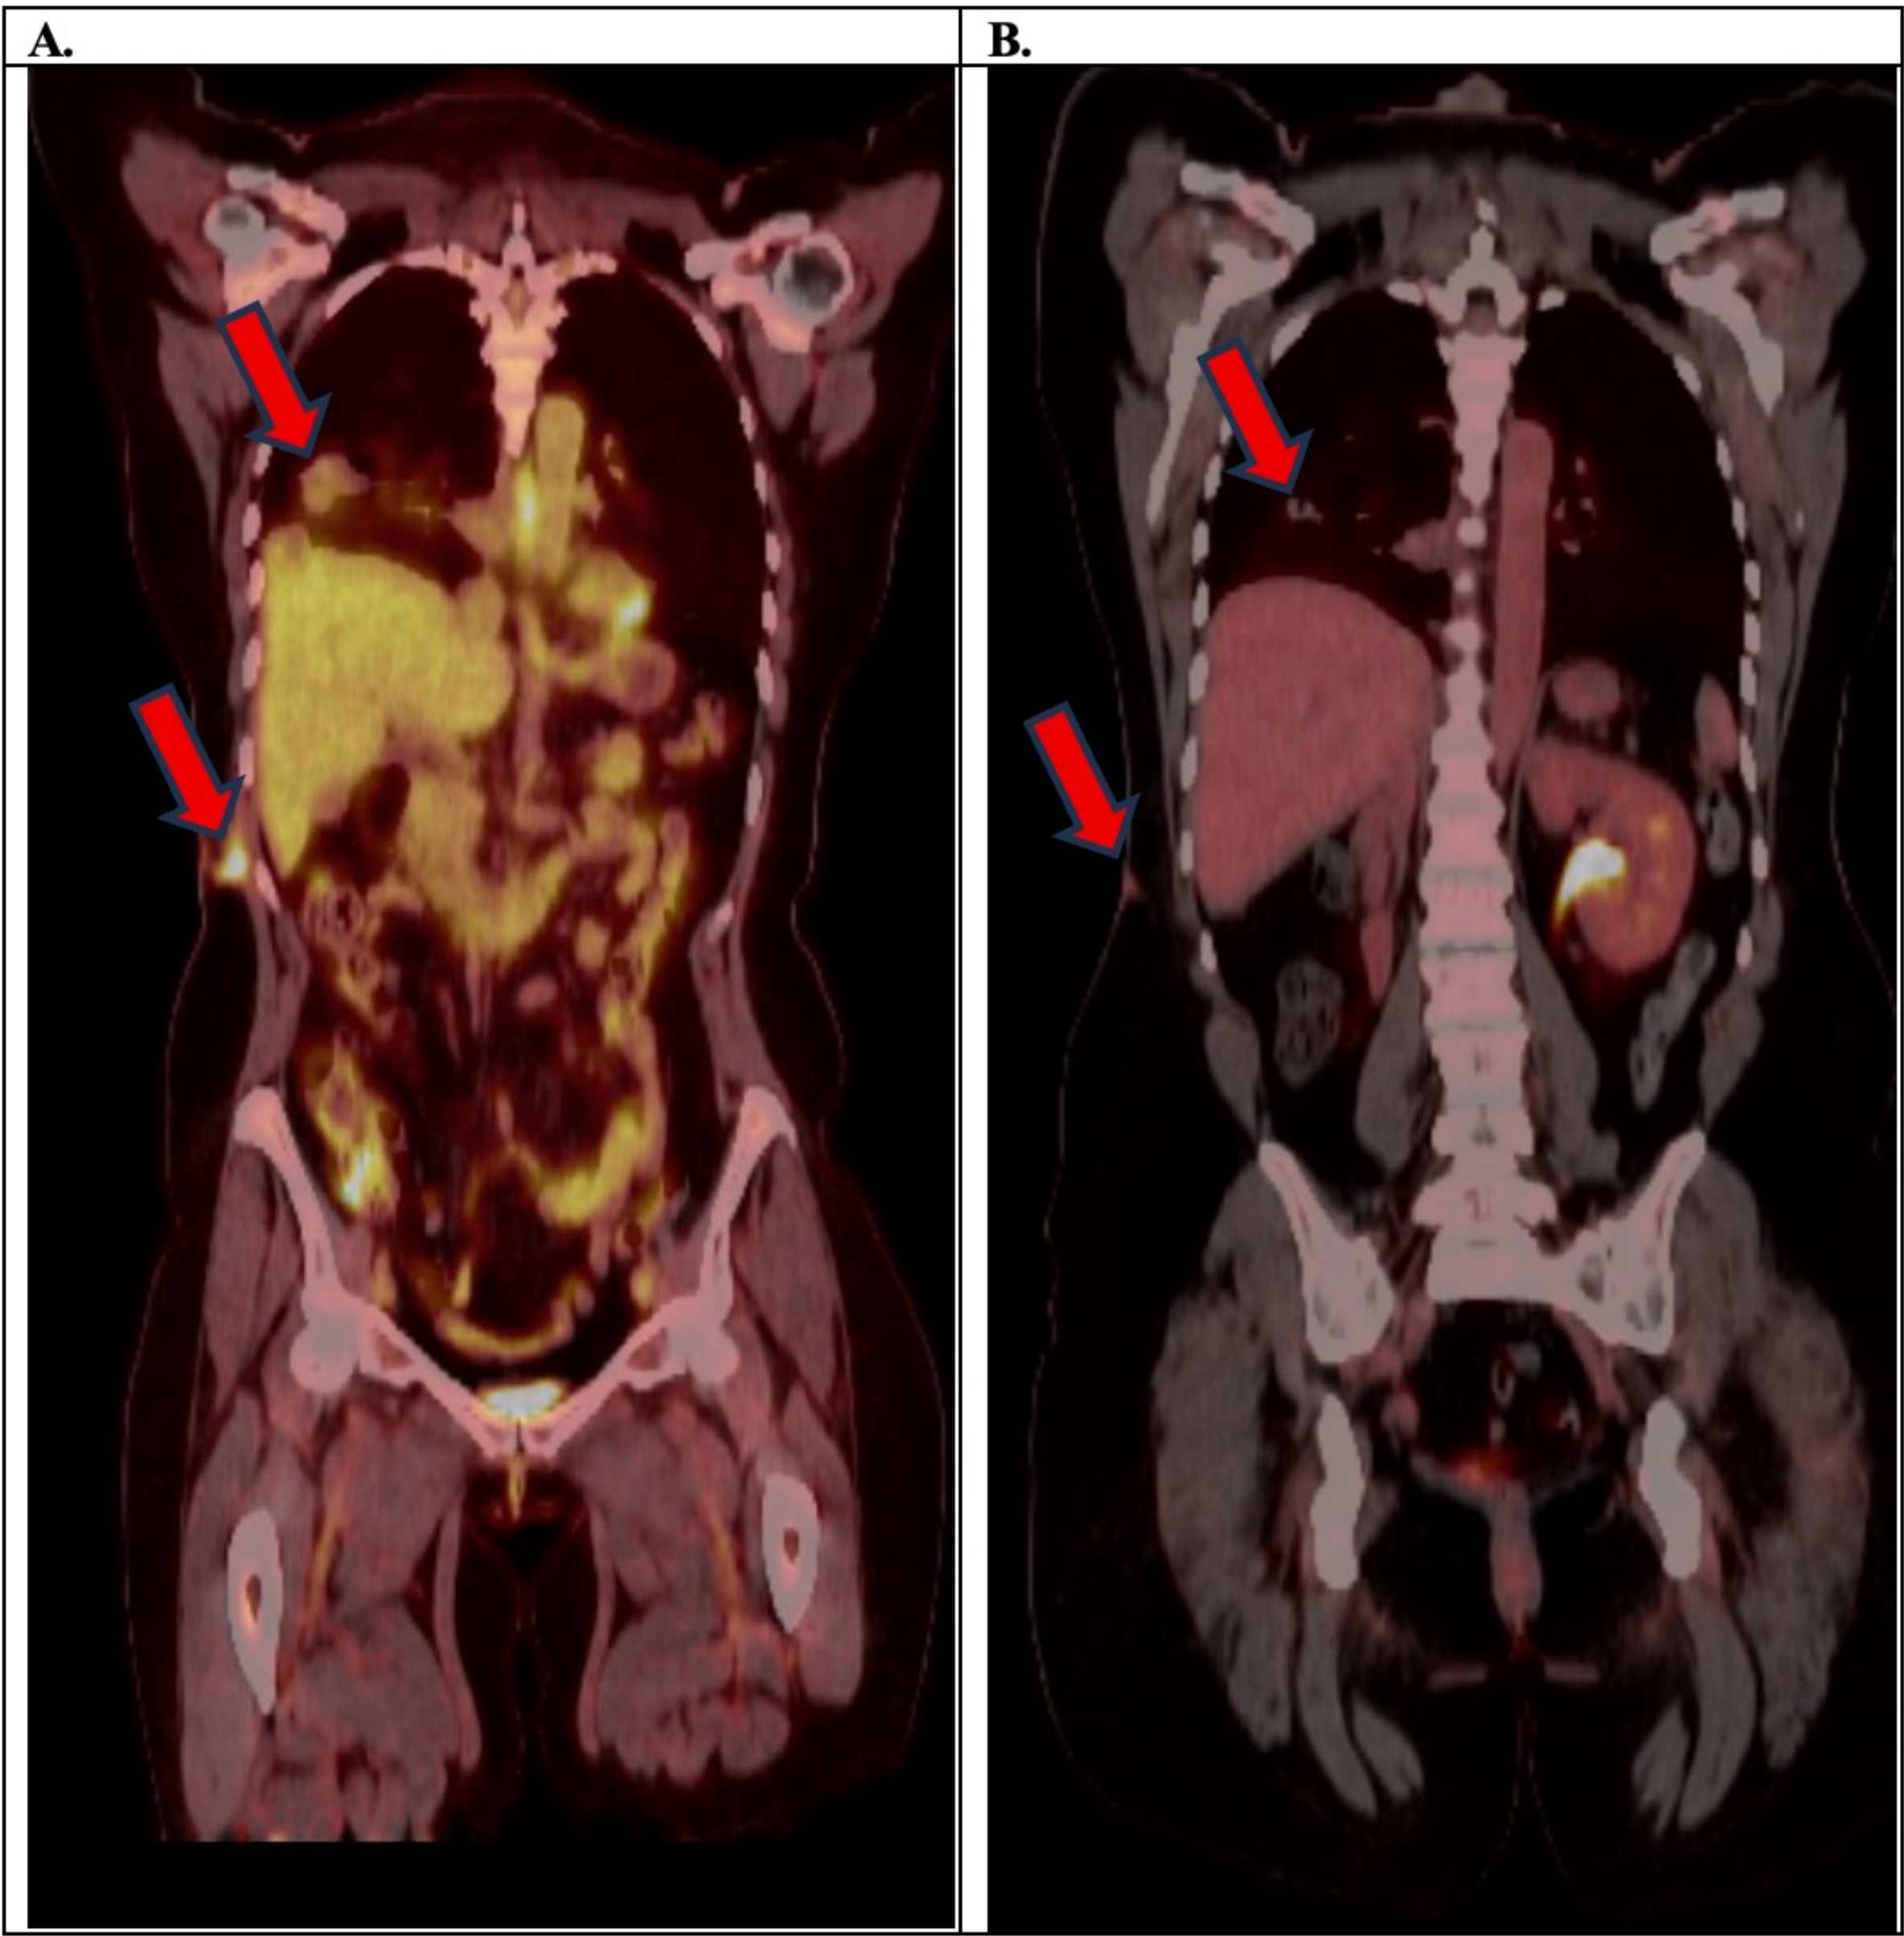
PET-CT showing response to single agent pembrolizumab. A. PET-CT obtained at the completion of three cycles of KEYNOTE-826 regimen with red arrows showing a right lower lobe and right chest wall metastatic implant. B. PET-CT obtained after cycle 19 of maintenance pembrolizumab showing marked decreased in the right lower lobe and right chest wall metastatic implant.
